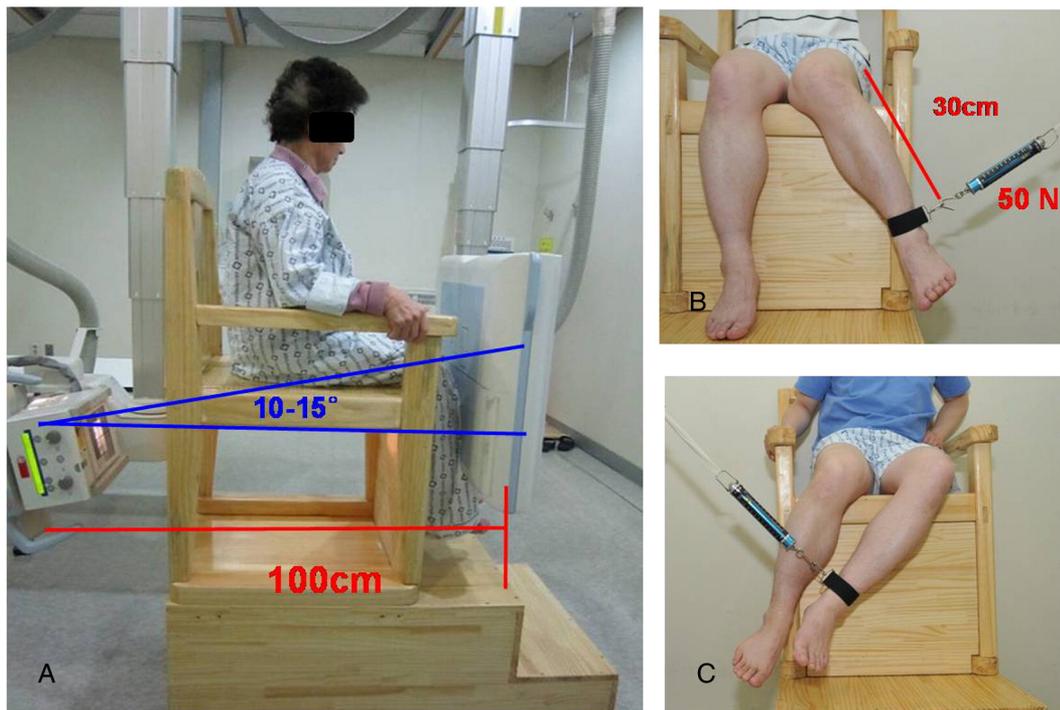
Measurement of varus and valgus laxity. (A) Positioning of patient for the radiograph. Beam is projected at an angle of 10°–15° and 100 cm is the distance between the x-ray tube and film cassette. Both epicondyles, posterior condyles and joint line are clearly visible by this method. Valgus (B) and Varus (C) stress views being taken to assess the laxity. 50 Newton (N) force being used, approximately 30 cm from the joint line using a spring scale.
